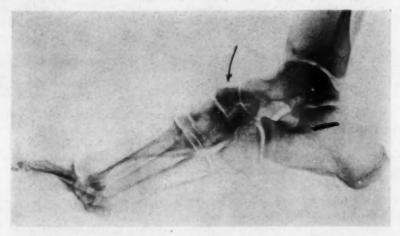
Roentgenogram of the right foot, taken five months before death. The dense periphery and fragmentation of the scaphoid bone may be noted. The patient had exquisite tenderness over this bone.
